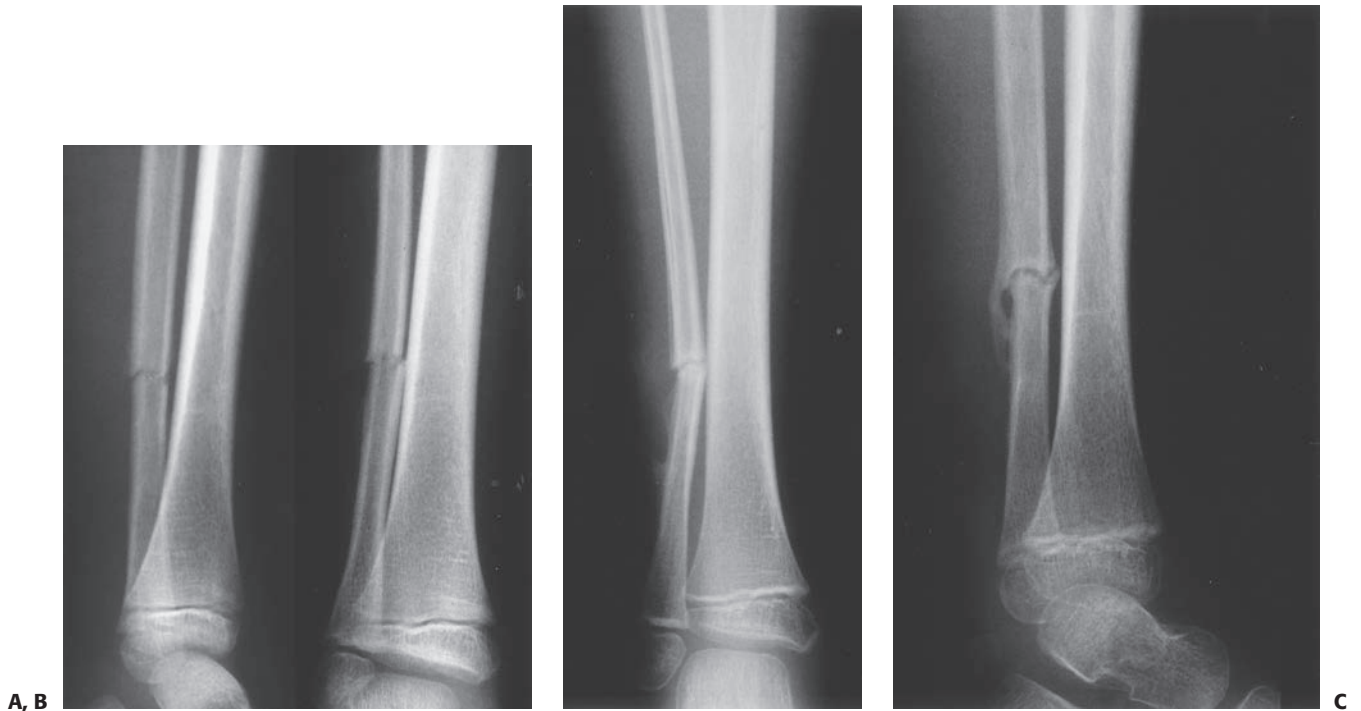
A: Anteroposterior and lateral radiograph of a 7-year-old child with an isolated open fibula fracture secondary to a bite by a pit bull. B: Anteroposterior radiograph 6 weeks after injury demonstrating consolidation at the fracture site. C: Lateral radiograph showing bridging callus 6 weeks after injury.
